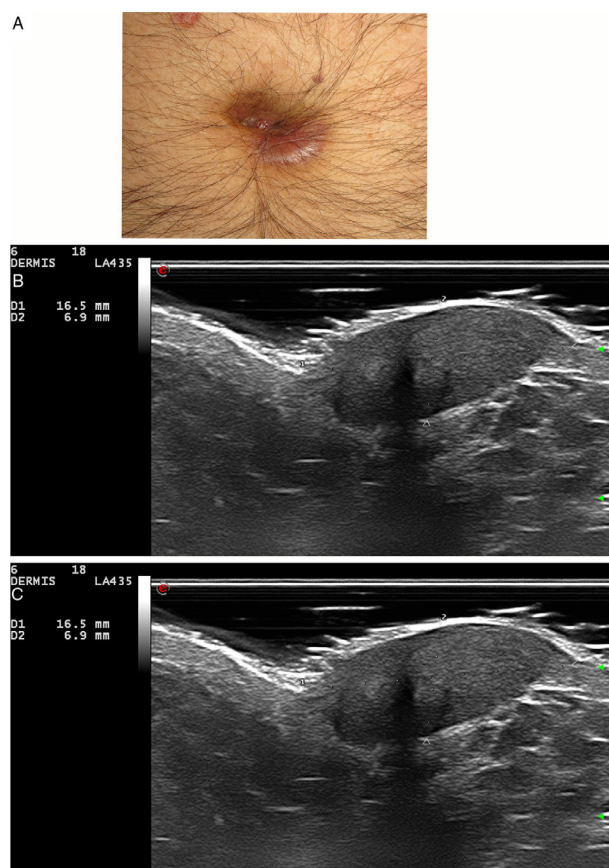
Granuloma faciale. A. Case 3: violaceous nodule on the umbilicus. B. Hypoechoic, well-defined and heterogeneous lesion in dermis and hypodermis, measuring 6.9 mm thick (18 MHz probe, B-mode). C. Marked increase in vascularity (18 MHz probe, color Doppler mode).
